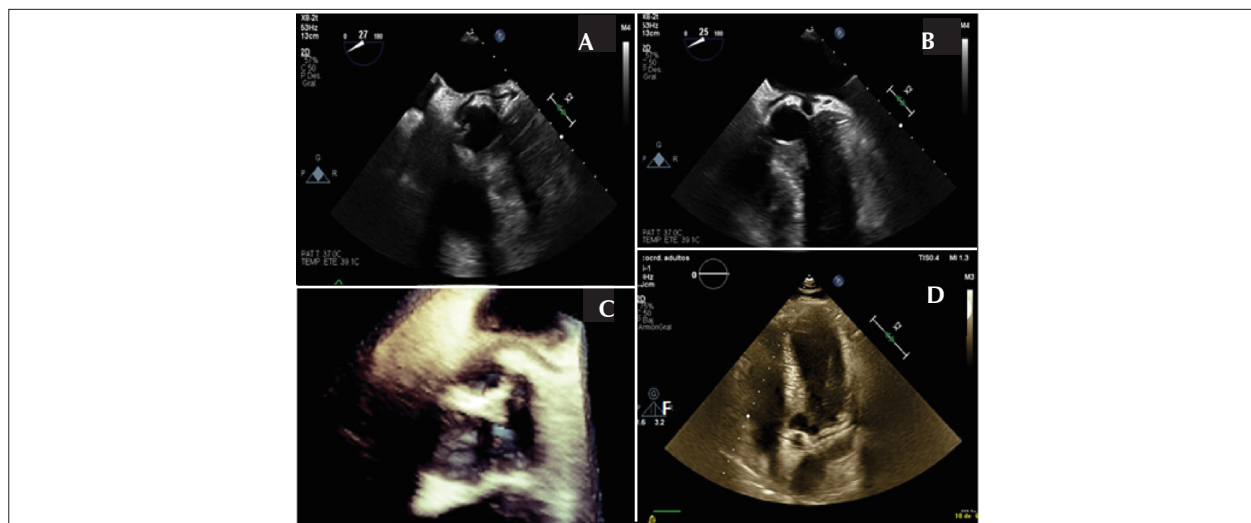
Panel A-B: Two-dimensional transesophageal echocardiography taken at the midesophageal (25–30°) level demonstrating the retroaortic anomalous coronary (RAC) sign. An anomalous circumflex artery origin from the non-coronary aortic sinus of Valsalva that extends behind the aortic root to its usual location in the atrioventricular groove is evident. Panel C: Three-dimensional echocardiography, zoom mode acquisition, and multiplanar reconstruction in which the coronary ostium and its angulation are seen. Panel D: Two-dimensional transthoracic echocardiogram demonstrating the RAC sign in the apical five-chamber view.
